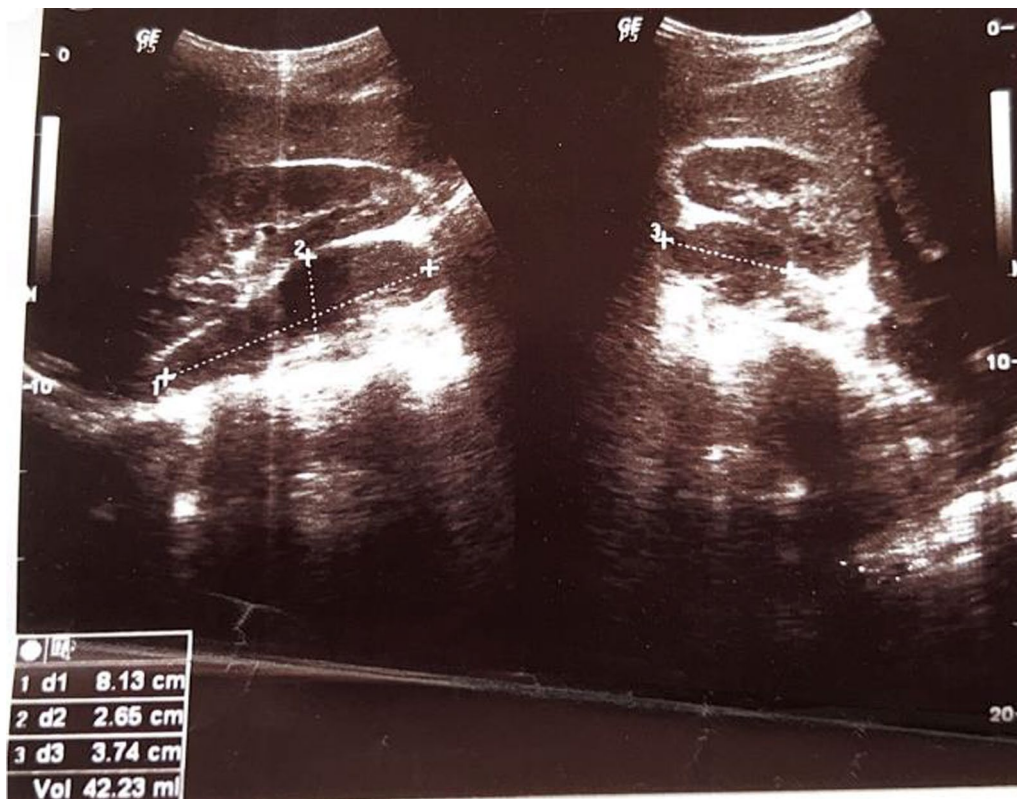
The right psoas abscess measured 8.1 × 2.66 × 3.74 cm and contained 42.23 ml of pus on ultrasound but more than 200 ml was drained after the incision
